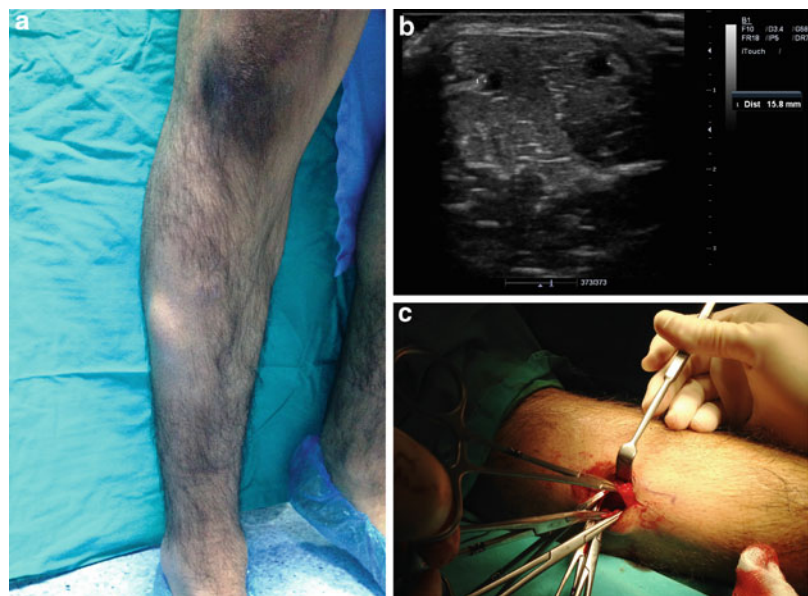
Tibialis anterior muscle hernia. (a) Gross appearance of the protruding mass on the anterolateral aspect of the right leg. (b) Longitudinal ultrasonography showing the bulging of tibialis anterior muscle. (c) Fascial defect easily seen during surgery
